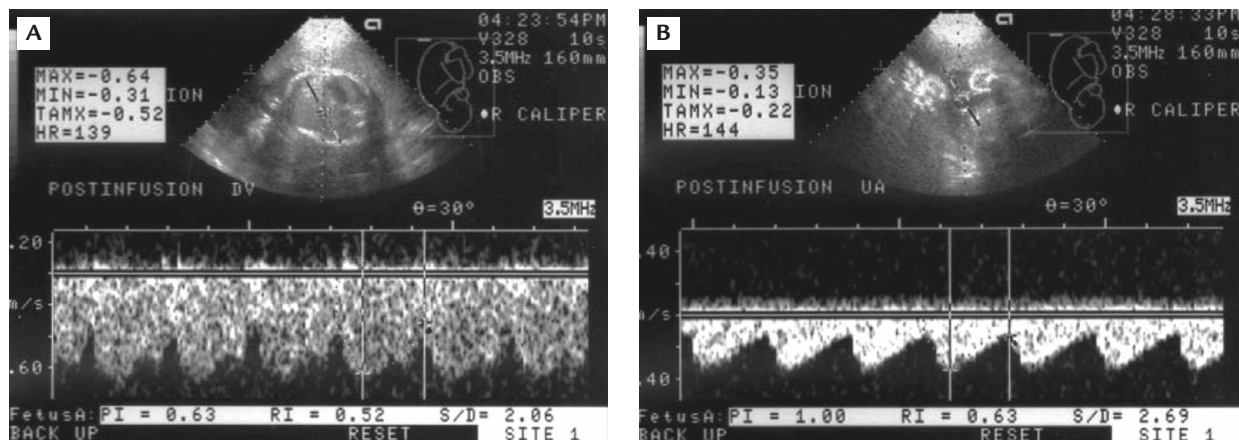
(A) Ductus venosus Doppler flow velocity. (B) Umbilical artery Doppler flow velocity.
